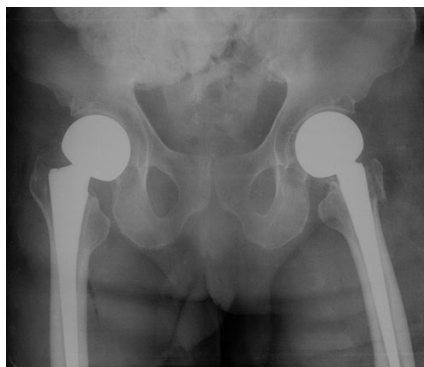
Post-operative anteroposterior X-ray of the pelvis with bilateral uncemented monopolar hemi-arthroplasties. A fragment at the left greater trochanter is the result of a pre-operative abductor avulsion fracture.
